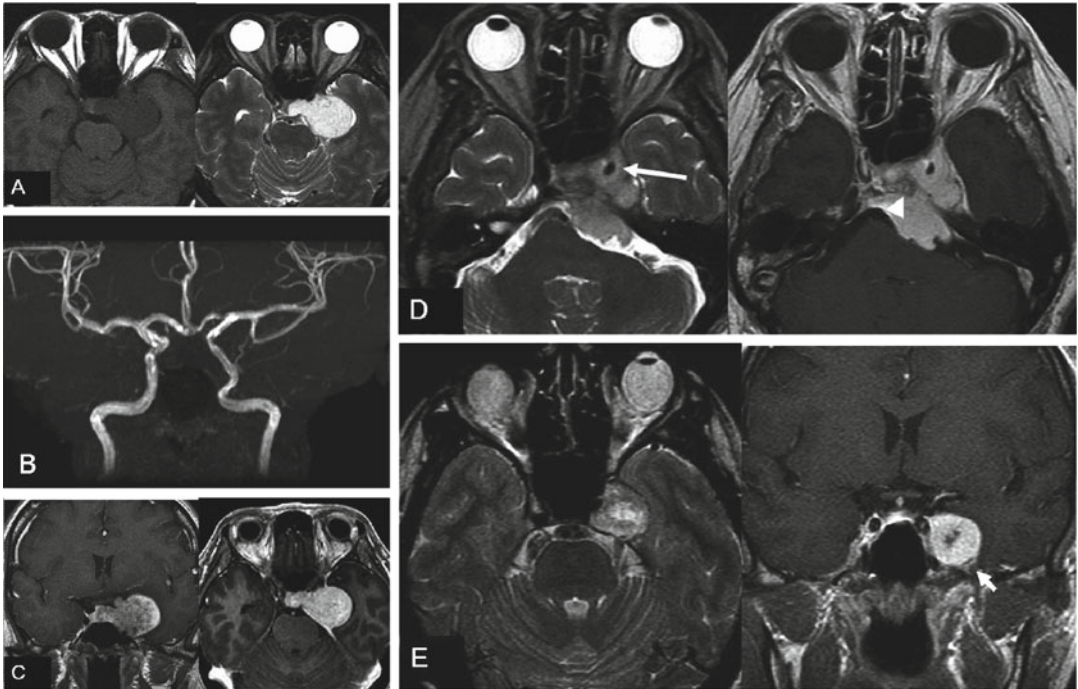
(a) to (c) are images of a left CS hemangioma from the same patient. (a): This CS hemangioma appears on MRI as a well-circumscribed, lobulated mass with hypointense or isointense signals on the T1-weighted image (*left*), and markedly hyperintense signals on the T2-weighted image (*right*). (b): The TOF MRA image reveals a normal caliber of the left internal carotid artery despite its encasement by the CS hemangioma. (c): On the early post-contrast coronal T1-weighted image, the tumor shows heterogeneous, mottled enhancement (*left*), which turns into strongly homogeneous enhancement on the delayed contrasted axial T1-weighted image (*right*).
